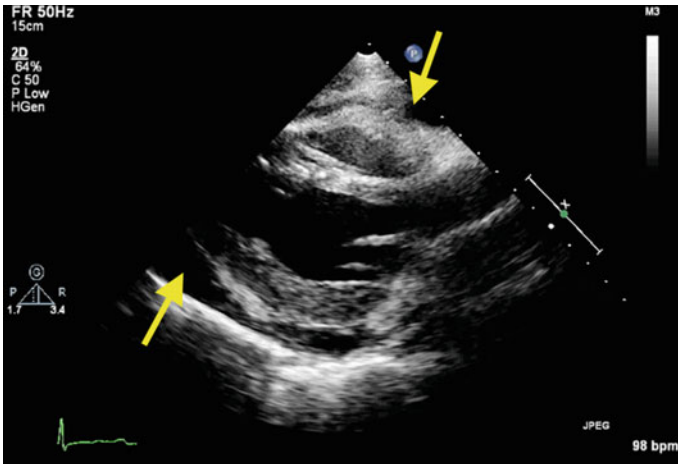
Parasternal SAX view demonstrating a pericardial effusion (yellow arrows) that resulted in hemodynamic instability. Please see Video 14.8 to observe the dynamic component of the effusion
